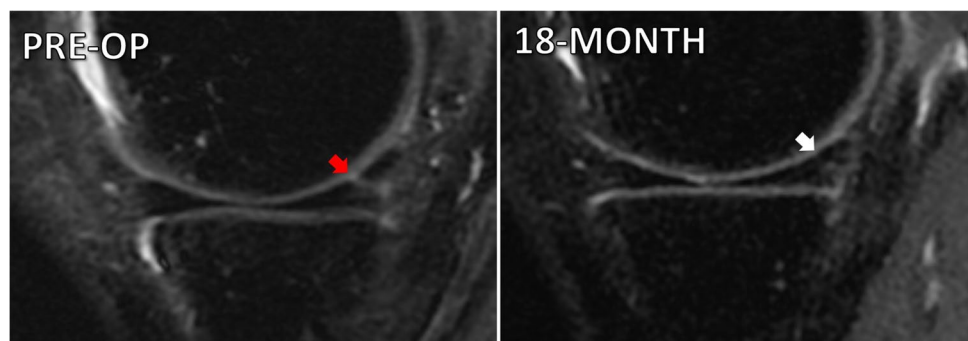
The vertical tear of the medial meniscus posterior horn and mid-body at the pre-operative status (red arrow) is completely healed at 18-month MRI evaluation (white arrow), but developing a peri-meniscal cyst (yellow arrowheads) (a). Another medial meniscus posterior horn tear (red arrow) is completely healed after 18 months (white arrow) but with the development of two different cysts (yellow arrowheads) (b)
